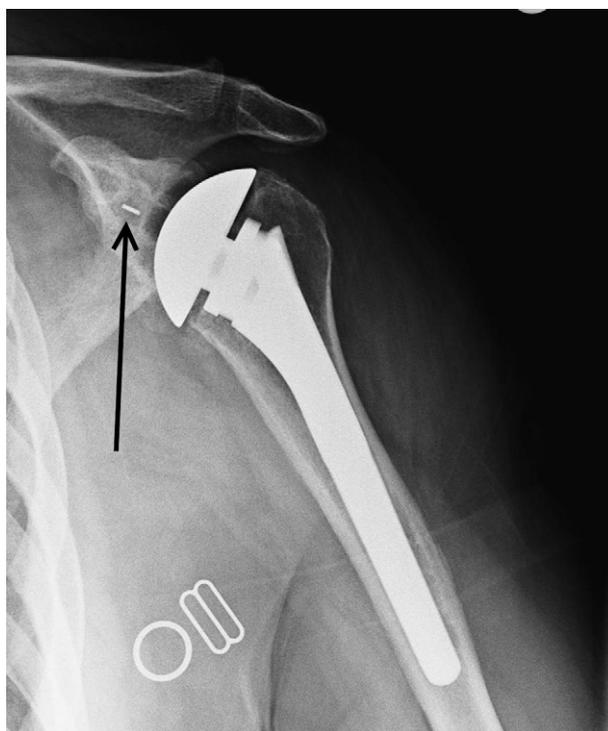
True anteroposterior radiograph of shoulder arthroplasty showing interdigitating radiodensity around fluted central peg (arrow) of glenoid component.
